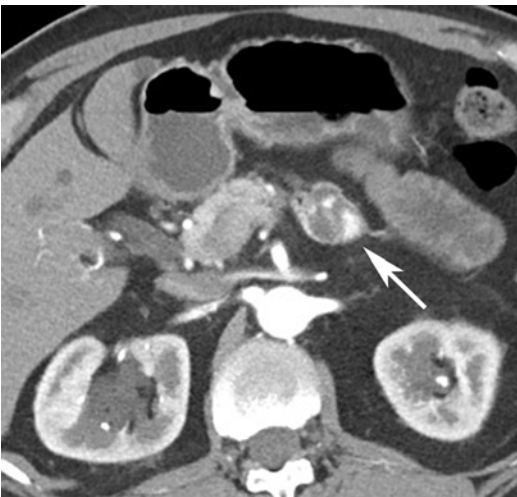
Axial contrast-enhanced CT in the arterial phase demonstrates a small cystic pancreatic lesion (*arrow*) with prominent hyperenhancing soft tissue nodularity along its margin, compatible with a cystic neuroendocrine tumor
